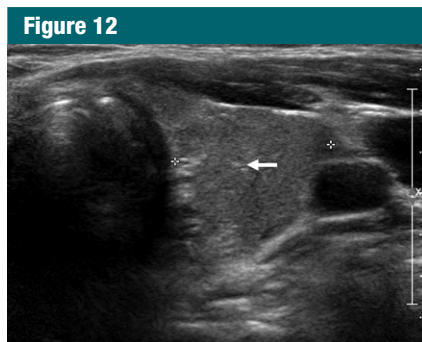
Sonogram of the left thyroid lobe in a 42-year-old man. Minute bright dots representing the speckle pattern of normal or nonmalignant tissue (arrow) should not be misinterpreted as punctate echogenic foci.
